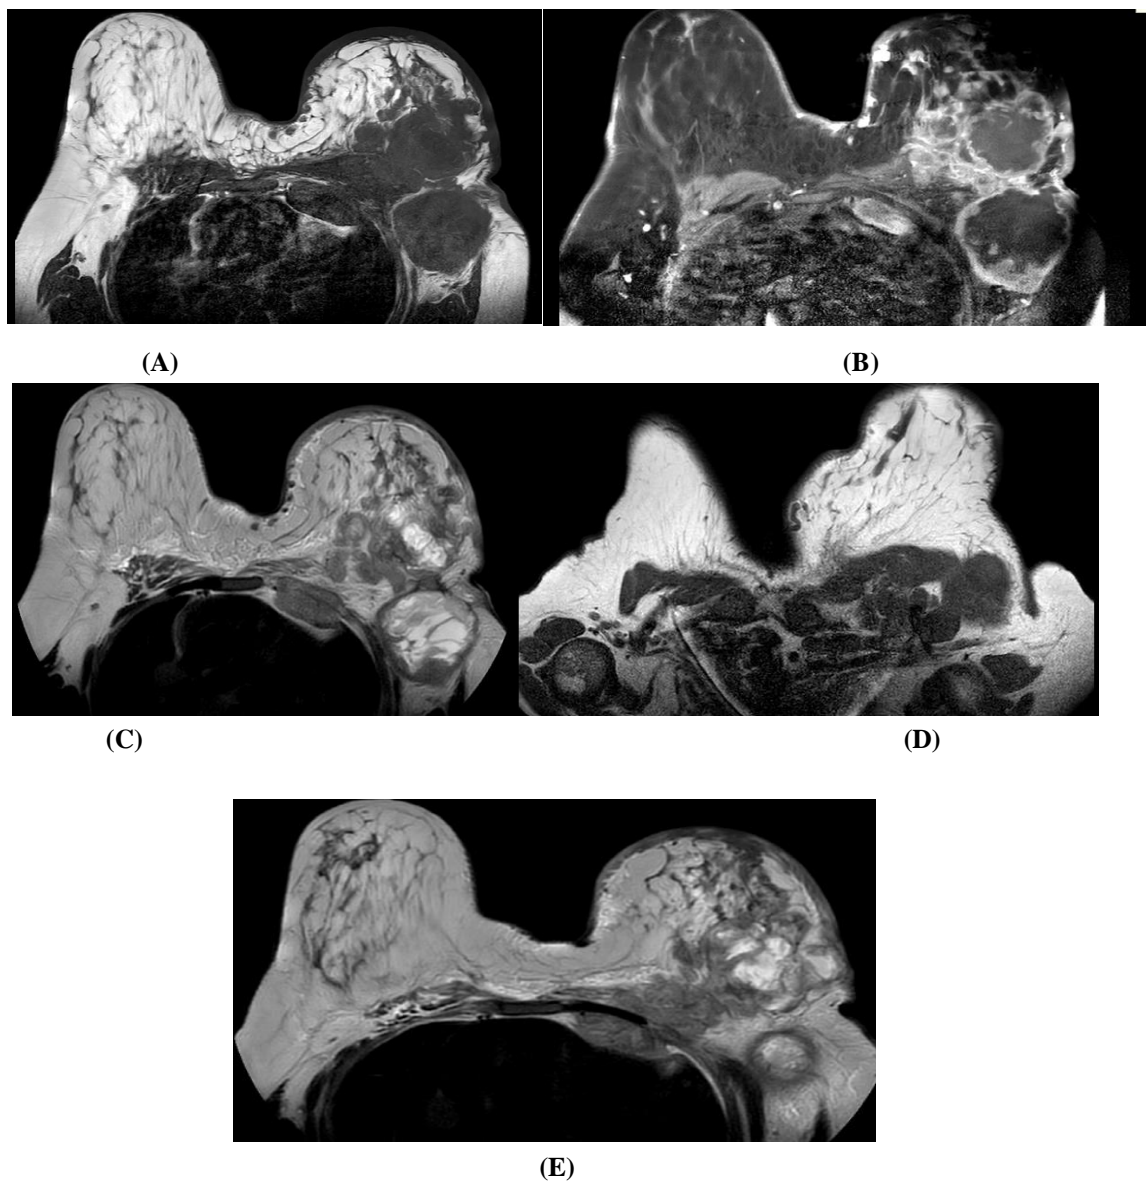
MRI breast study of 41 years old female patient with left sided innumerable neoplastic looking left breast and axillary soft tissue lesions with pathological axillary & subpectoral and supracalvicular lymph nodes. (BI-RADS-5) ; (A) & (B) & (C) Axial T1WI pre and post contrast and Axial T2WI showed :
